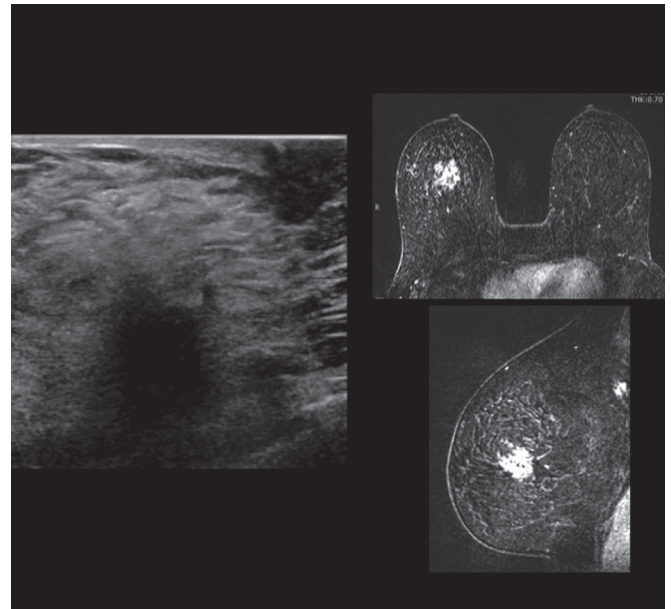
Right breast ultrasound confirmed a hypoechoic, shadowing mass with irregular margins and a bilateral breast MRI showed a spiculated mass with mixed kinetics including washout.
